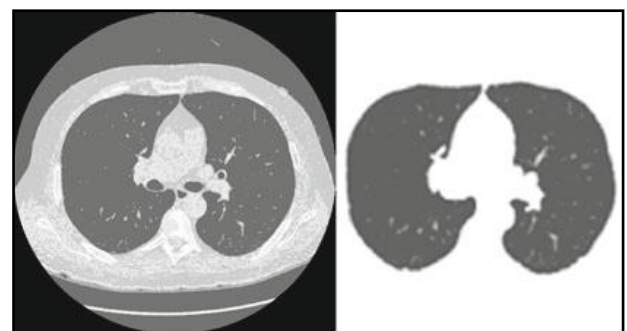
A segmented lung CT image: original (left) and segmented images (right) [9]
